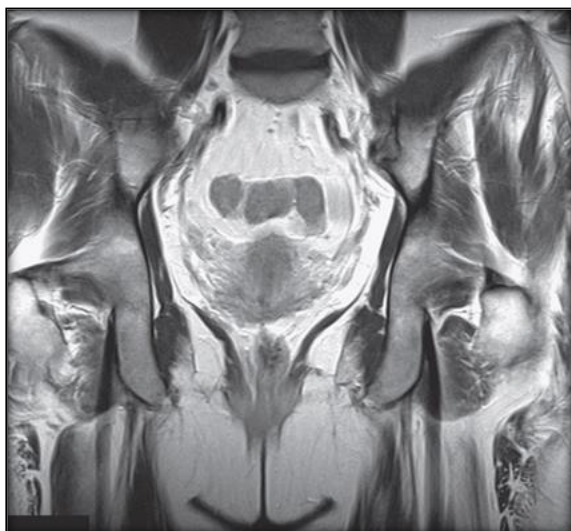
Coronal T1 MR image of the pelvis
